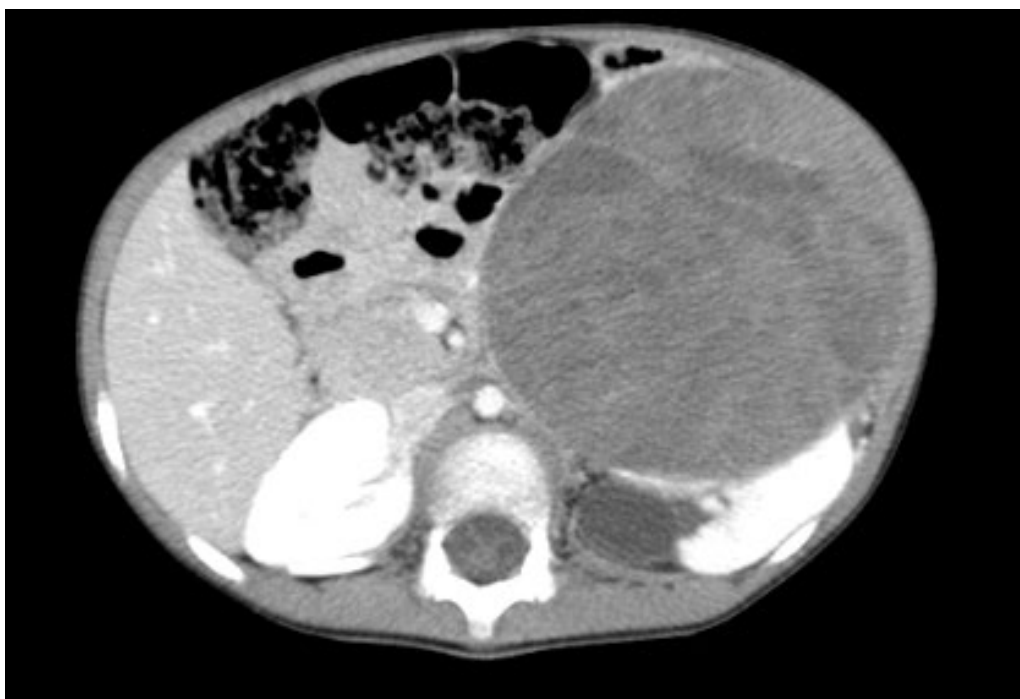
Axial CT image revealed a massive tumor of the left kidney
